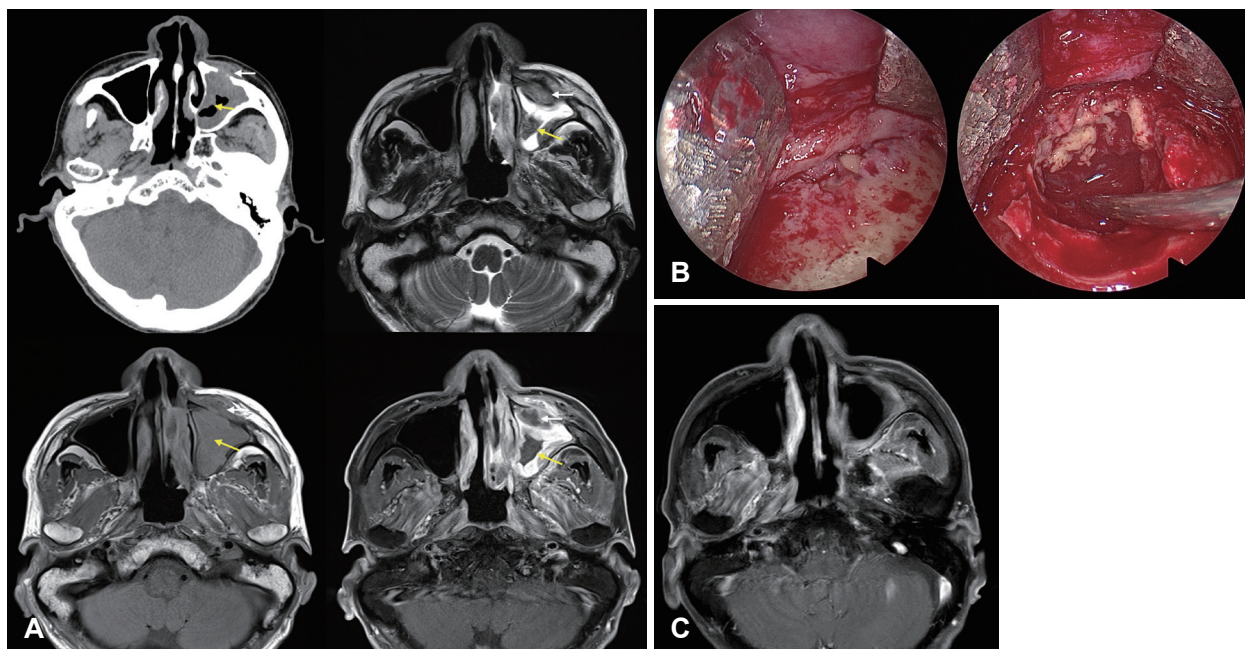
MR images and intraoperative finding of a patient with chronic granulomatous invasive fungal sinusitis. A: CT scan revealed bony destruction in the anterior wall of the left maxillary sinus and an irregular enhancing soft tissue lesion extending into the left maxillary sinus, cheek, infraorbital canal, and superior orbital wall (white arrow). These findings suggested chronic invasive fungal sinusitis vs. malignancy in the left maxillary sinus. MR images reveal an irregular T2 low signal intensity soft tissue lesion in the left maxillary sinus and its anterior and posterolateral walls. There is bony destruction extending to the left cheek (white arrow) and retroantral fat area. Irregular central T2 low signal intensity lesion within maxillary sinus (yellow arrow) shows calcific density on CT, suggesting fungus ball. The findings indicated that chronic invasive fungal sinusitis is more probable than a neoplastic condition in the left maxillary sinus. B: The anterior wall of the maxilla and infraorbital nerve were necrotic and completely resected via Caldwell-Luc operation. C: Postoperative gadolinium-enhanced MR image showed no remnant LoCE lesions.
